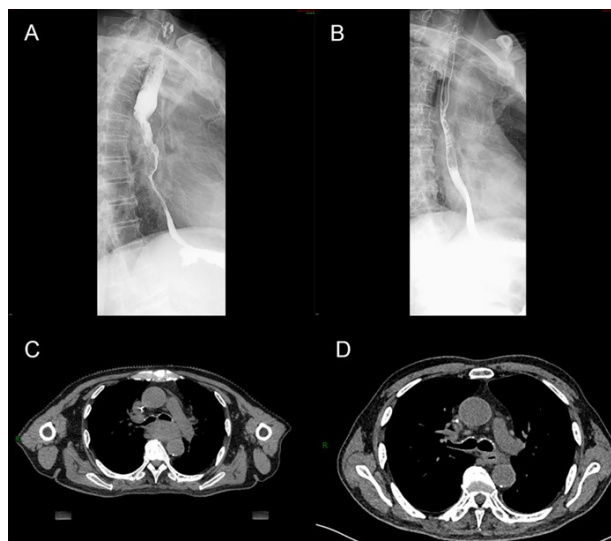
Barium swallow imaging and CT images of esophageal cancer patients before and after radiotherapy. (A) Barium swallow imaging before radiotherapy in esophageal cancer patients; (B) Barium swallow imaging after radiotherapy in esophageal cancer patients; (C) CT image before radiotherapy in esophageal cancer patients; (D) CT image after radiotherapy in esophageal cancer patients.
